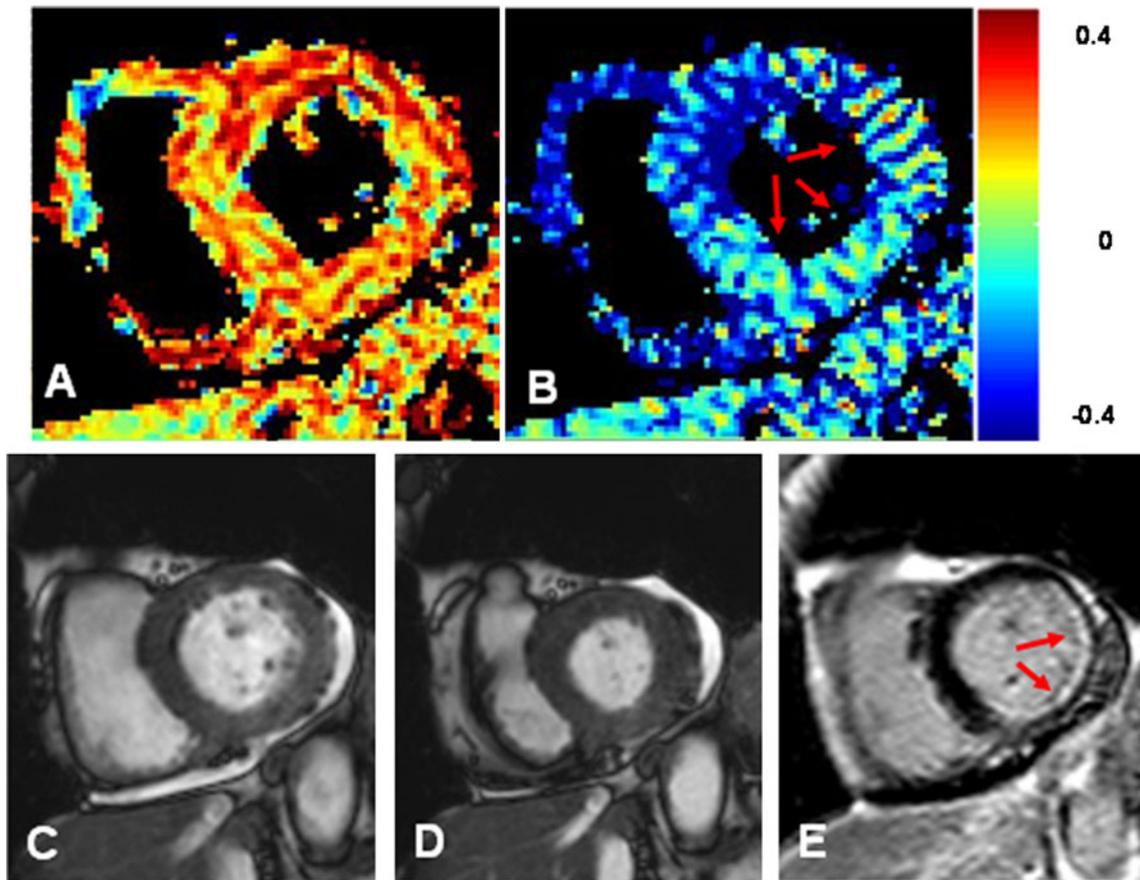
85-year-old man with inferolateral old MI. e1 strain map (a), e2 strain map (b) obtained by DENSE MRI, cine MR images during systole (c) and diastole (d), and LGE MRI (e). E2 map revealed impaired circumferential strain in the inferolateral wall (b, arrows).
